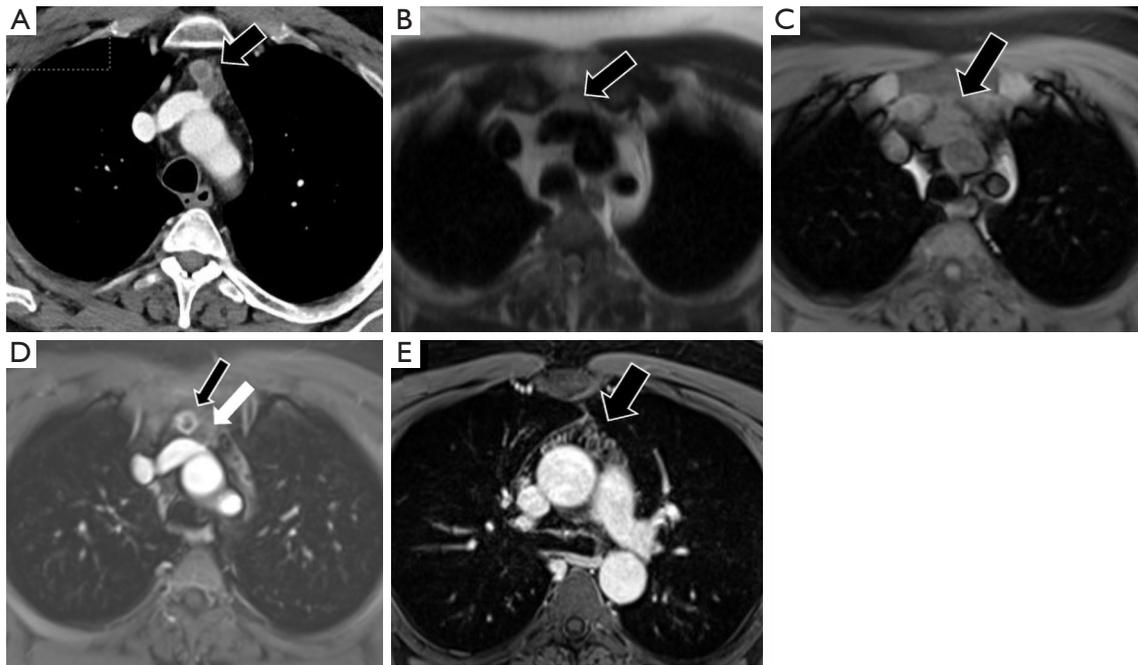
47-year-old male with a multiloculated (acquired) thymic cyst. CT images after the administration of contrast demonstrates multiple low-density lesions in the prevascular mediastinum (A). One of these lesions (black arrow) demonstrates peripheral high density. MRI evaluation of this lesion demonstrates intermediate to low T2 (B) and high T1 (C) signal compatible with hemorrhagic/proteinaceous components. After the administration of gadolinium, there is peripheral enhancement surrounding this lesion compatible with inflammatory changes in the capsule (D, black arrow). Other adjacent cystic lesions demonstrate simple fluid imaging characteristics and do not enhance after contrast (D, white arrow). Surrounding strands of residual thymic tissue are noted (E, black arrow). This lesion was consistent with a multiloculated thymic cyst on pathology. CT, computed tomography; MRI, magnetic resonance imaging.
